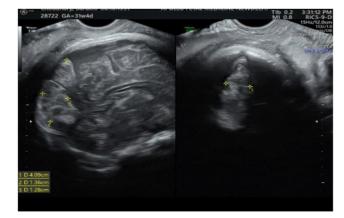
Antenatal ultrasound suggestive of the venous sinus thrombosis at 31 weeks
